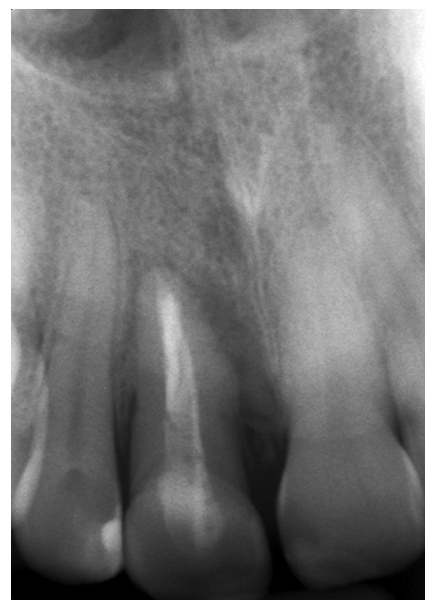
Preoperative radiograph showing fracture of right maxillary central incisor.
